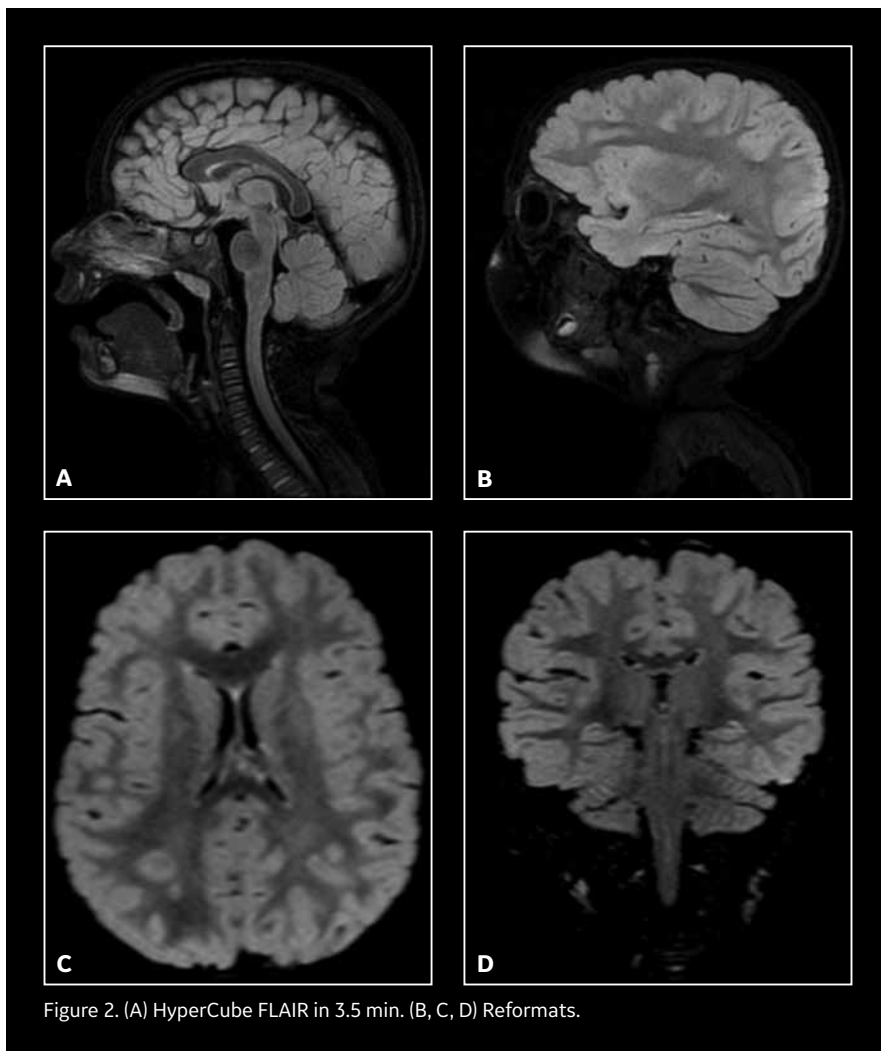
(A) HyperCube FLAIR in 3.5 min. (B, C, D) Reformats.
